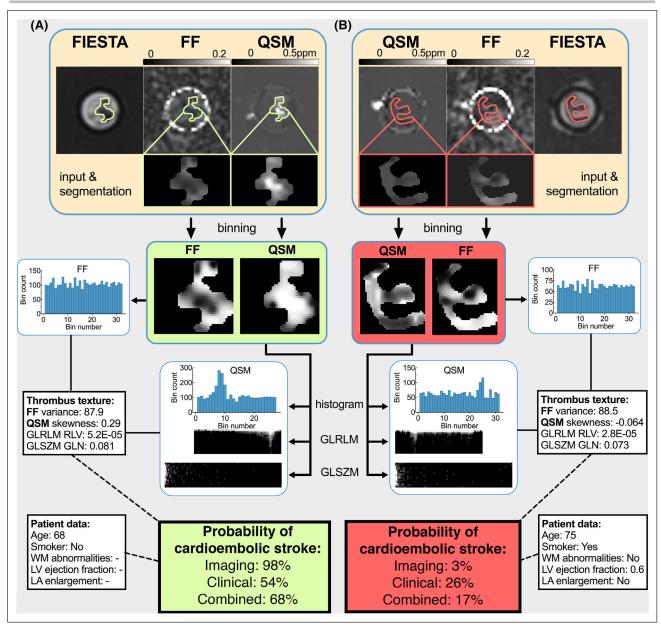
Overview of model processing steps for representative cardioembolic (A) and large artery atherosclerosis (B) thrombi. Segmentations derived from FIESTA-C images are applied to naturally coregistered quantitative susceptibility mapping (QSM) and fat fraction (FF) maps, which are binned before extraction of the histograms and matrices used to derive the 4 predictive texture features for model input. In (A), a patient with known atrial fibrillation did not undergo echocardiography and was missing multiple variables included in the clinical model, uncommon in this cohort but typical of clinical data in general, which resulted in a weak cardioembolic cause prediction that was greatly improved through the addition of thrombus texture information. In (B), all patient clinical features were available and the addition of thrombus texture information of a noncardioembolic cause. GLN indicates gray-level nonuniformity; GLRLM, gray-level run-length matrix; GLSZM, gray-level size zone matrix; LA, left atrial; LV, left ventricular; RLV, run-length variance; and WM, wall motion.
